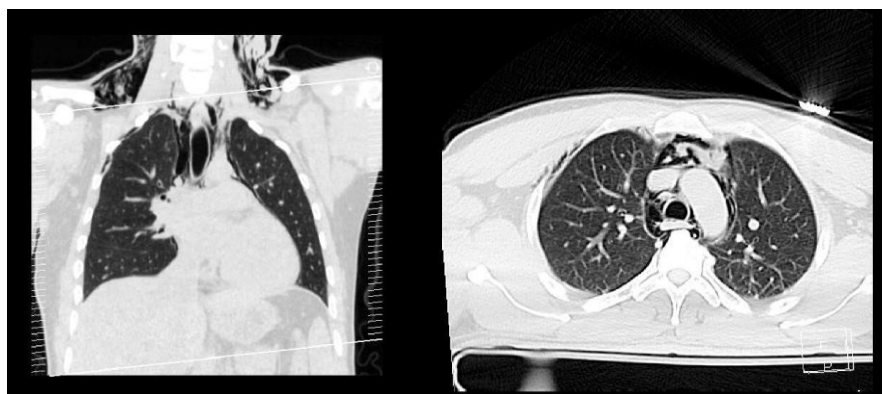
Coronal and axial lung window computed tomography of the chest demonstrates bilateral lower neck subcutaneous and anterior chest wall emphysema as well as pneumomediastinum.
